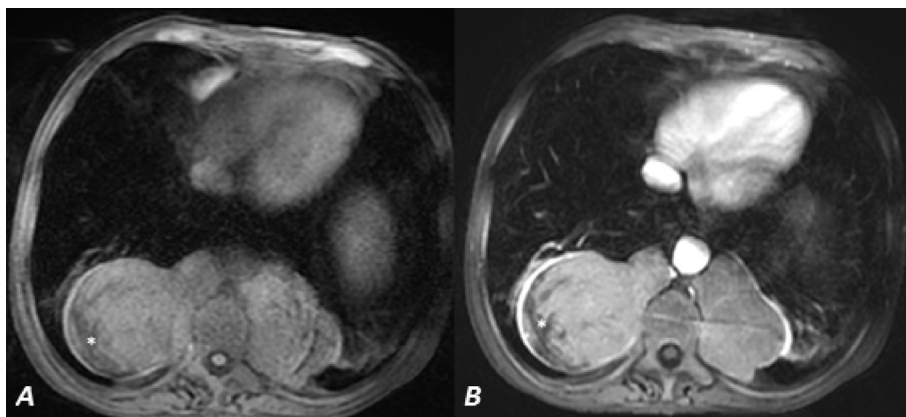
Chest MRI. Pre (A) and post-contrast (B) fat suppressed T1-weighted gradient-echo sequences shows mild contrast enhancement and fat foci (*).
